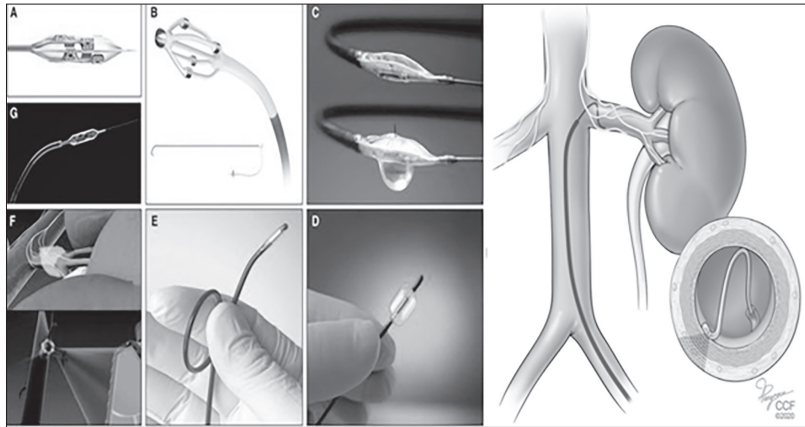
There are currently various RDN devices available to reduce sympathetic nerve activity in the kidney, thereby lowering blood pressure. The image on the right depicts the mechanism of denervating the centripetal and centrifugal nerve fibers surrounding the renal artery. These devices include A, the Boston Scientific V2 Renal Denervation System; B, the St. Jude Medical multi-electrode RDN system; C, the MedSystems mapping-based ablation system; D, the ReCor Medical PARADISE system for transdermal sympathetic denervation; E, the ultrasound-based sympathetic denervation system; F, the Kona Medical system for acoustic-based sympathetic denervation; and G, the Covidien-Maya balloon-based denervation system.
